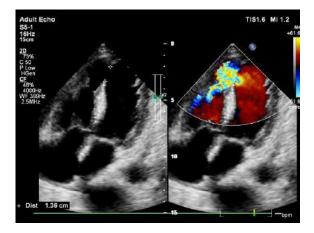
TTE in apical 4 chamber view demonstrates in dual window view the VSD defect and the left to right shunt.
